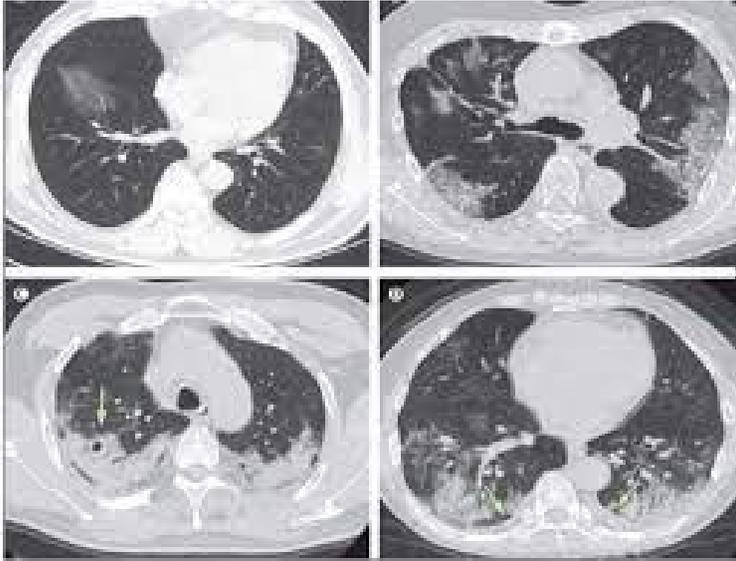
Sample CT and X-ray images in Covid -19 patients.(3)
